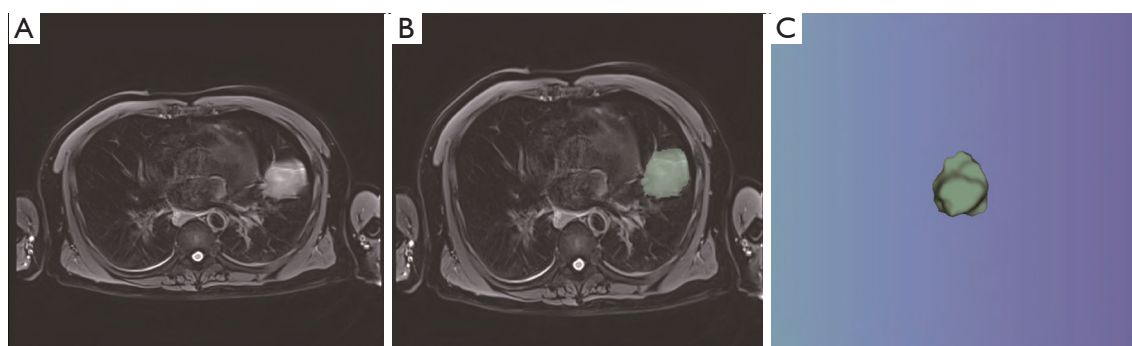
Delineation of lung cancer VOI on MRI-T2WI. (A) MRI-T2WI; (B) manual delineation of ROI (green area); (C) the VOI obtained. VOI, volume of interest; MRI, magnetic resonance imaging; ROI, region of interest; T2WI, T2-weighted imaging.
